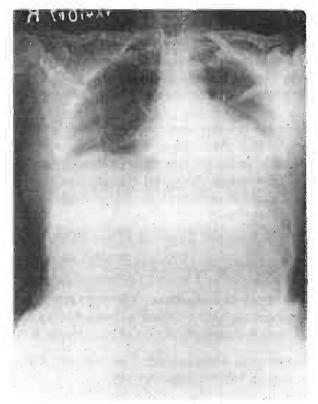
Preoperative chest X-ray showing the absence of pulmonary metastases.
